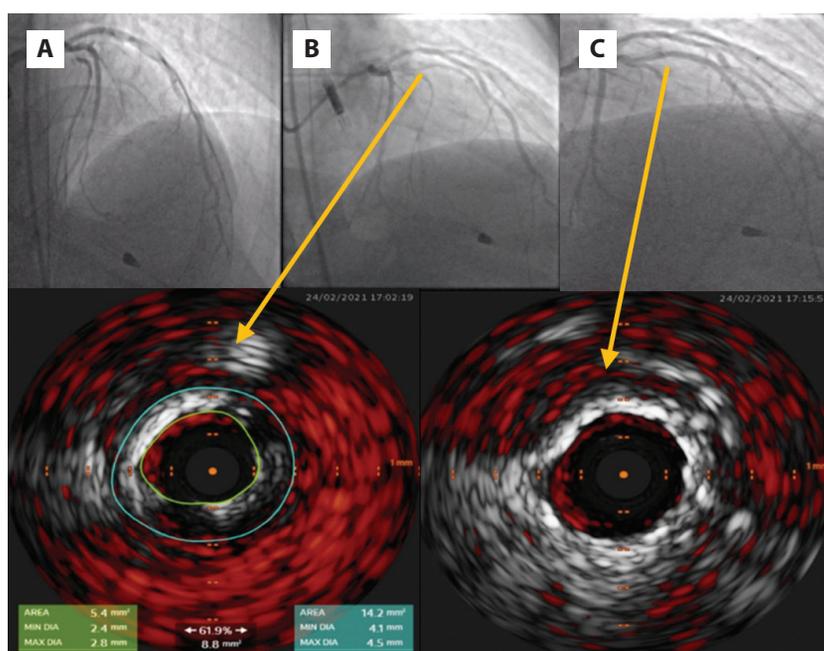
A. Initial left descending artery (LAD) arteriography. B. LAD arteriography after recanalization with intravascular ultrasonography (IVUS) showing significant stenosis in the medial segment of LAD. C. Final effect with proper stent apposition confirmed via IVUS
